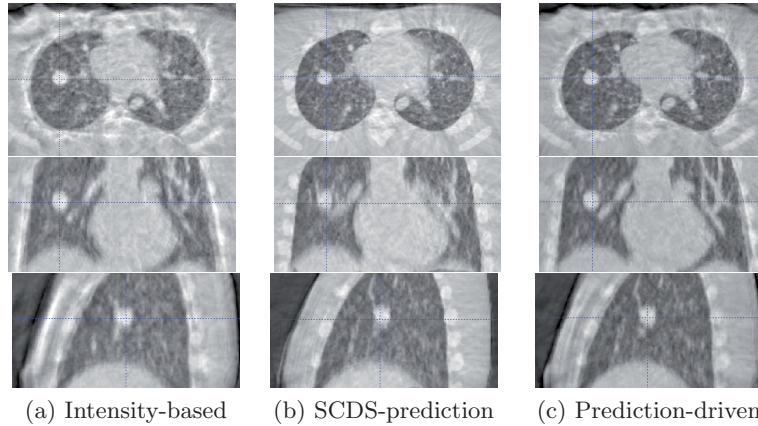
Atlas image comparison of NCAT data set tests. The axial (the first row), coronal (the second row) and sagittal (the third row) slices are compared. a) The Fréchet mean atlas image of the CBCT sequence. b) The atlas image from the SCDS-prediction results. c) The atlas image from the prediction-driven atlas formation method.
